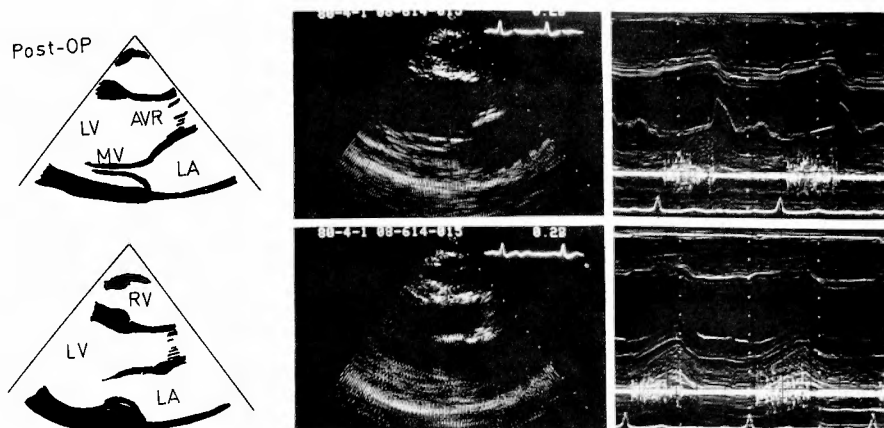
The ultrasonic tomocardiogram in Case 1 taken 4 years postoperatively shows a decrease in width of interventricular septum and posterior left ventricular wall. But movement of the interventricular septum is paradoxical still now.
